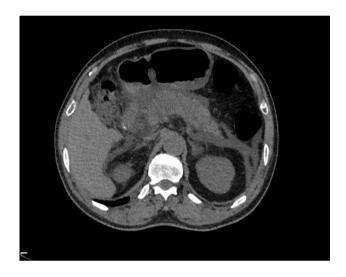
Axial cut of plain CT abdomen of patient B suggestive of peripancreatic fat stranding
